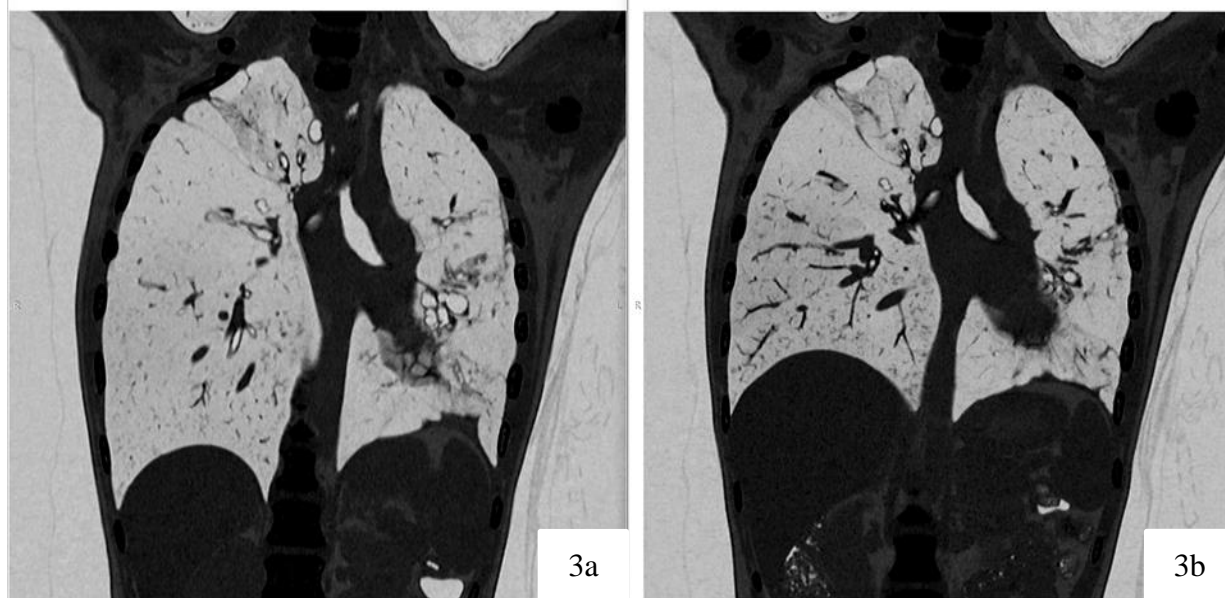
Figure 3a: Coronal images of expiratory chest CT, lung window showing bronchiectasis in bilateral lungs. Few subpleural bullae are evidence in apical segment of right upper lobe.
